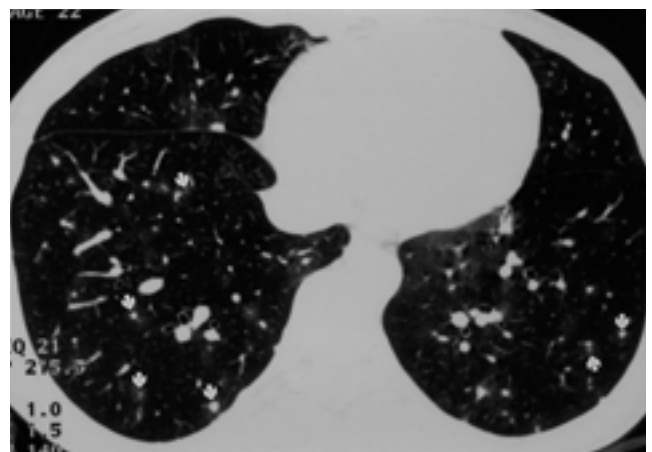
Kaposi's sarcoma in a 29-year-old woman who received renal transplantation 5 months ago. HRCT scan at level of basal lungs shows multiple small nodules with CT halo sign (arrows).
